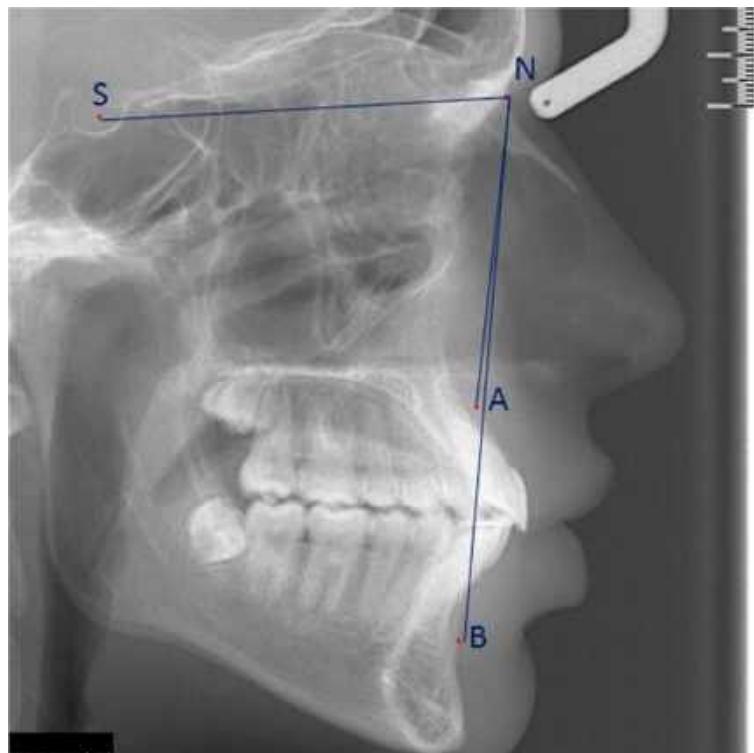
Lateral cephalometric radiograph showing the identified landmarks and the measured angles.
